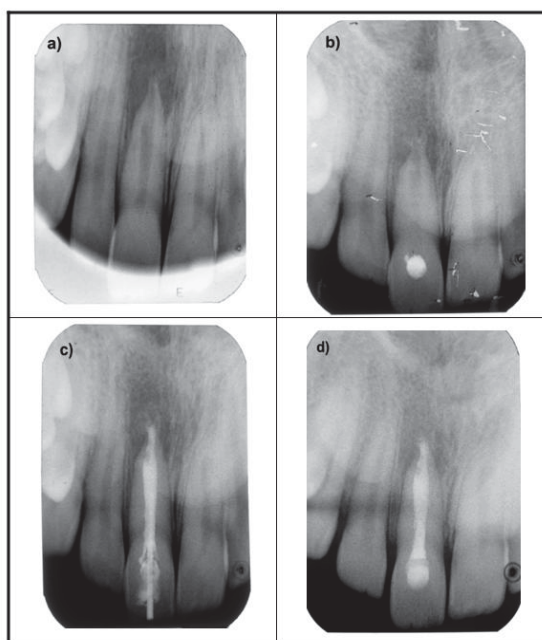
a) Radiographic view at the first visit, large periapical lesion; b) Radiographic view after 1 month, calcium hydroxide dressing; c) Radiographic view of completed root canal obturation (MTA, sealer and gutta-percha); d) Radiographic follow-up at 3 months, demonstrating osseous repair of periapical lesion.
